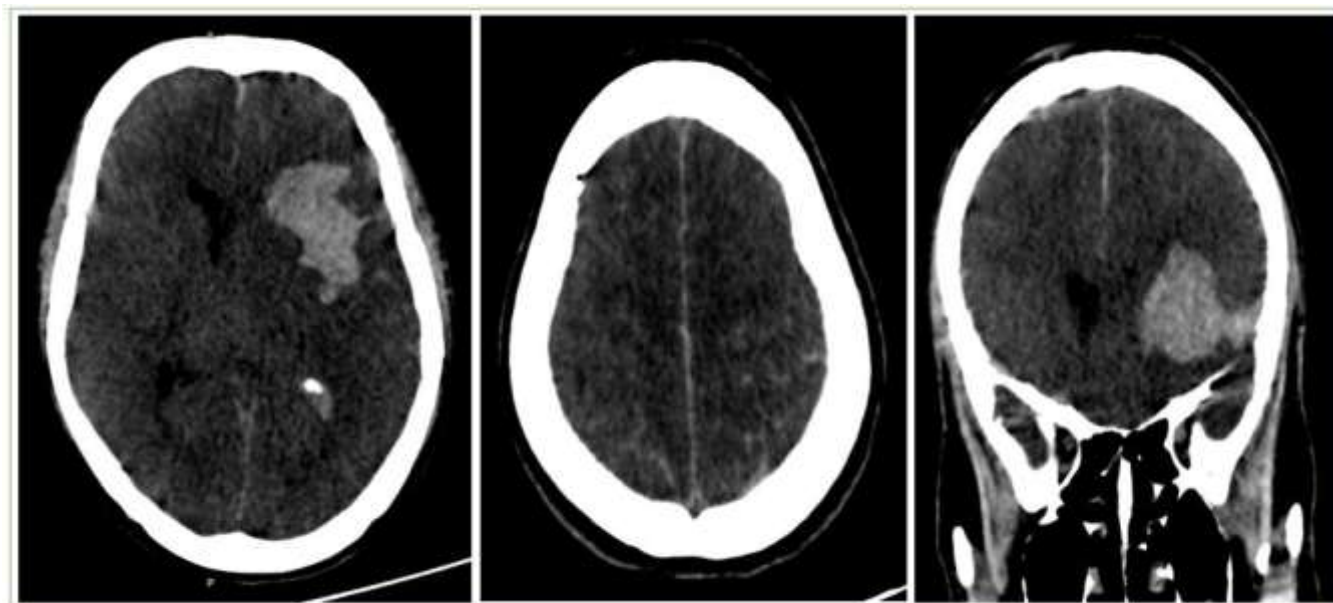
Unenhanced computed tomography of brain shows acute intraparenchymal hemorrhage in left frontal and insular cortex with surrounding edema and associated midline shift of 7mm.
